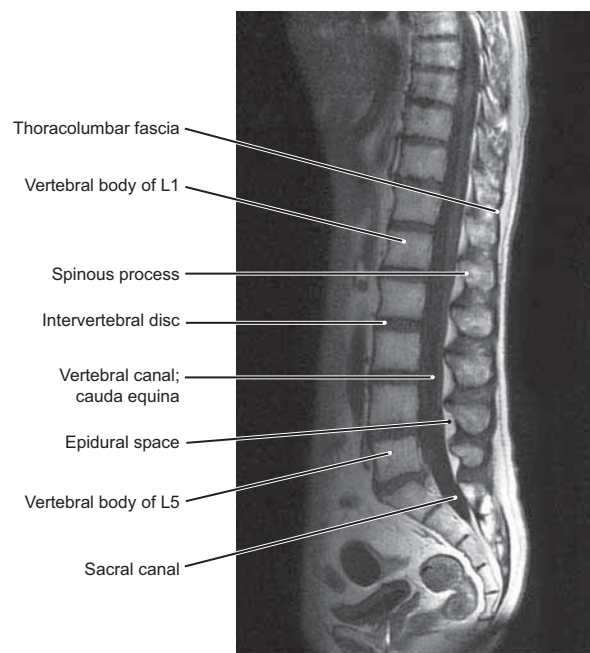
Magnetic Resonance Image of the Lumbar Vertebrae (Median Sagittal Section)
